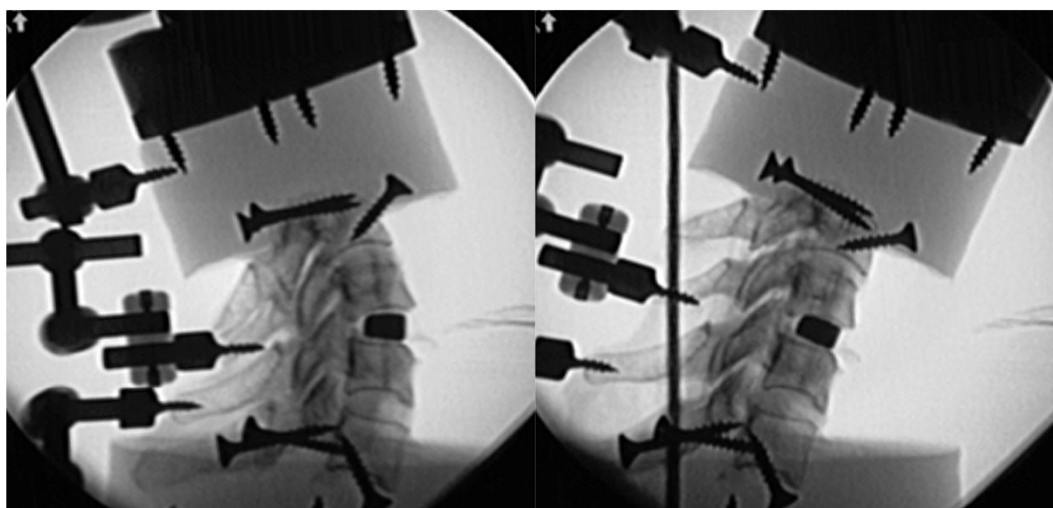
Radiographs in maximum flexion and maximum extension in the post implanted state.
